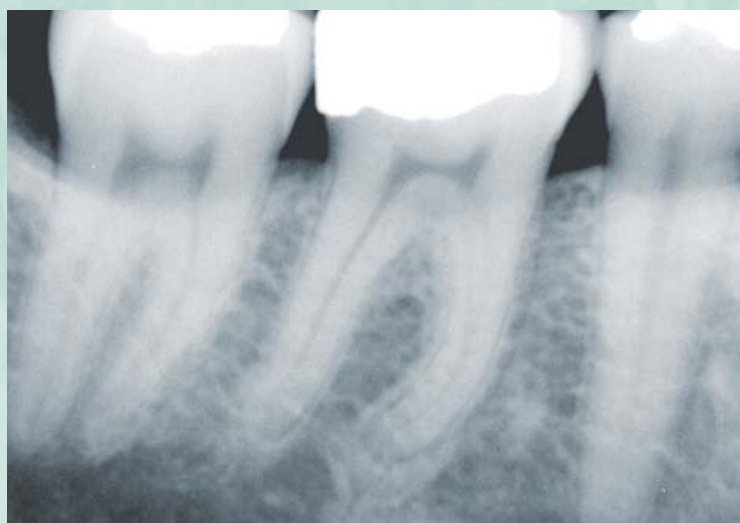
Radiograph denotes deep restoration of longstanding duration. Referring dentist saw no pathology and thought it best to observe since the amalgam restoration was intact.
